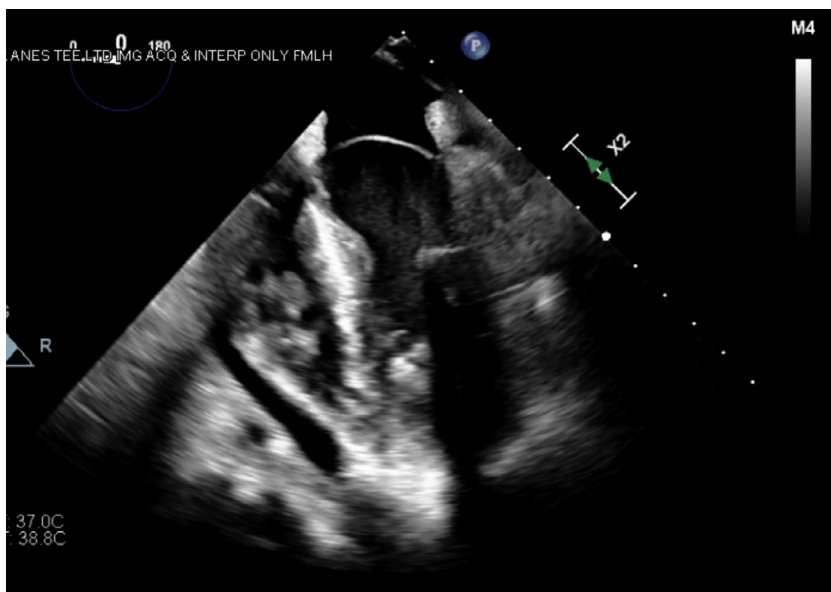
Midesophageal 4-chamber transesophageal echocardiography view during systole.
